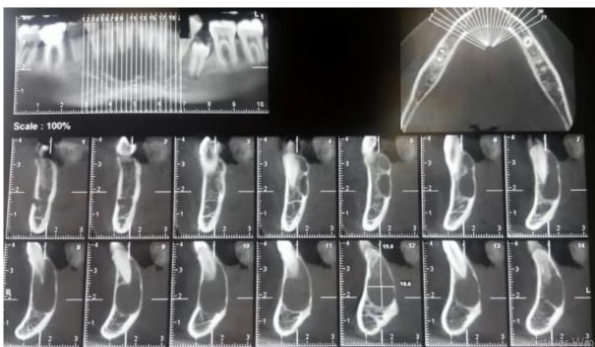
CBCT showing a hypodense zone without perforation of the cortex of the vestibular or lingual side or root invasion [5]
